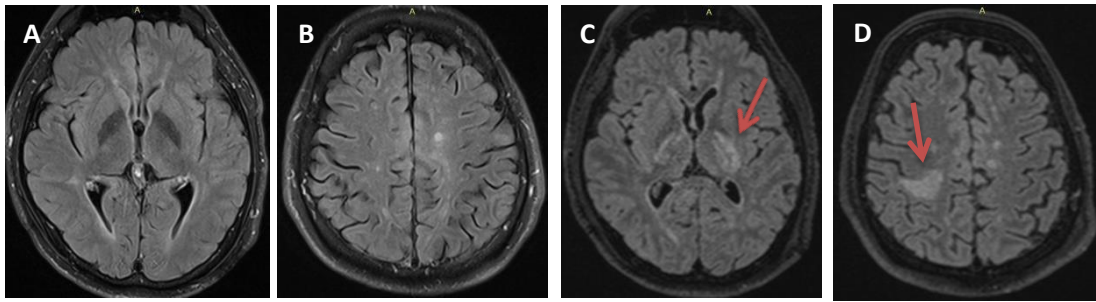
A, B: Baseline demyelinating lesions in brain MRI in February 2021. C, D: Brain MRI in May 2021 after intubation. New demyelinating lesions in the corticospinal tracts bilaterally and in the white matter of the right parietal lobe (red arrows).
